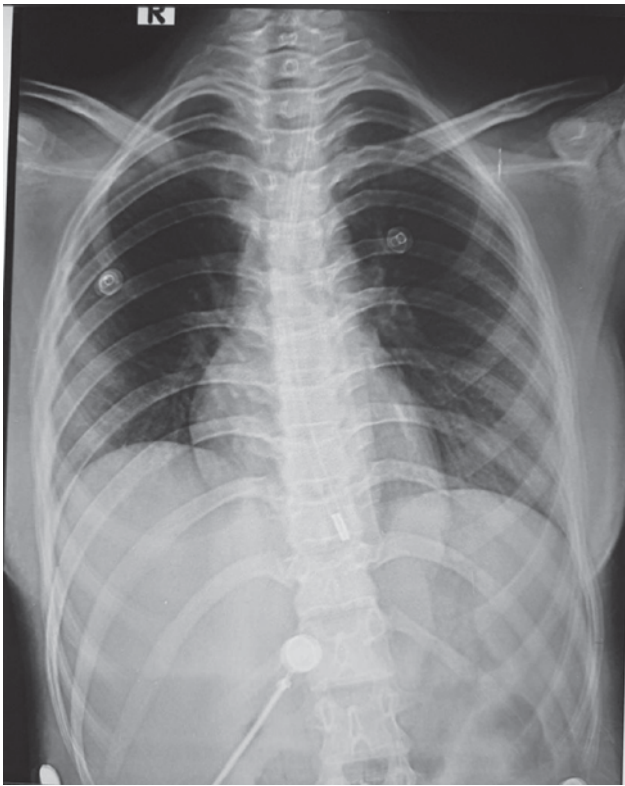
Xray of chest P/A view is normal. There are shadows of multiple wires
